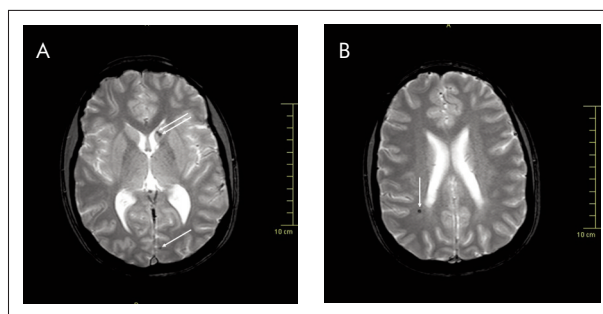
Axial T2-weighted FFE MRI images of the brain. A shows two hypointense lesions (2-3 mm) within the head of left caudate nucleus, and one subcortical occipital lesion (3 mm); B shows one lesion (3 mm) in the right parietal region, behind the ventricular horn. These lesions are compatible with CCM
